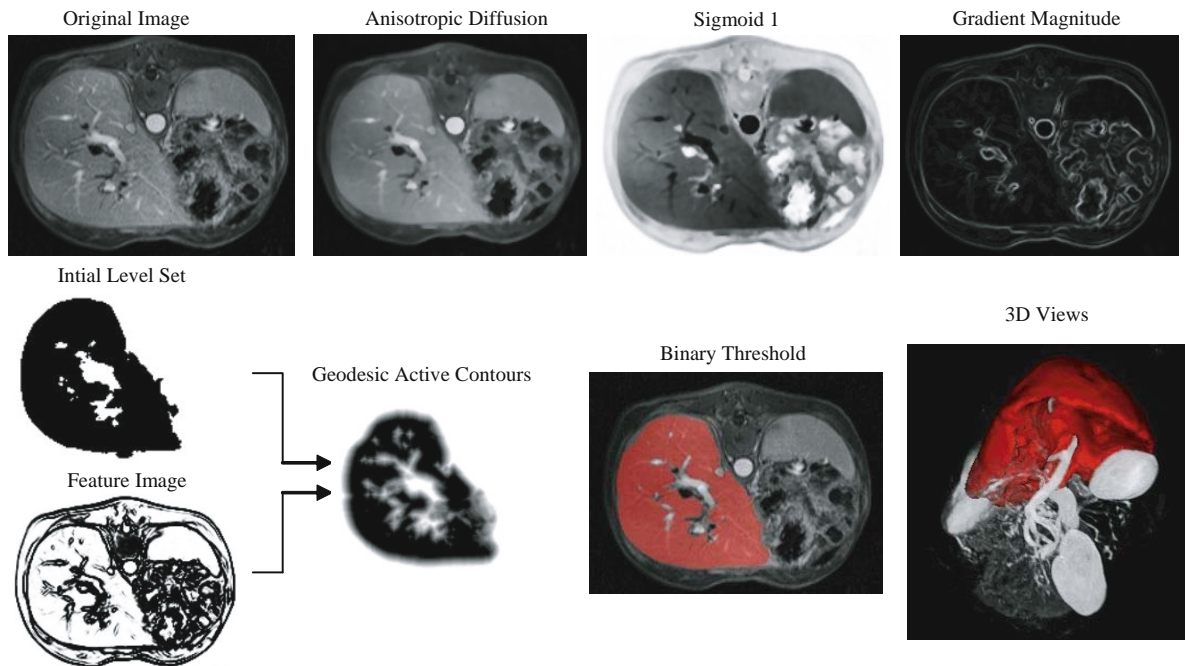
Result of a liver segmentation based on MRI. Fast marching produces the initial level set and the GAC algorithm segments the contour of the liver.
